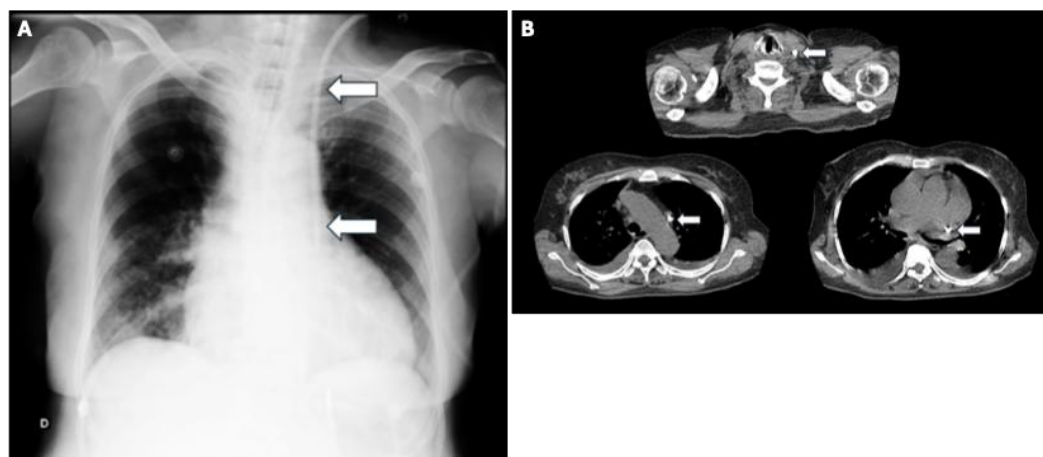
A. X-ray showing a hemodialysis catheter on topography of a persistent left superior vena cava. B. Computed tomography (axial sections) showing a hemodialysis catheter in a persistent left superior vena cava (arrows).
